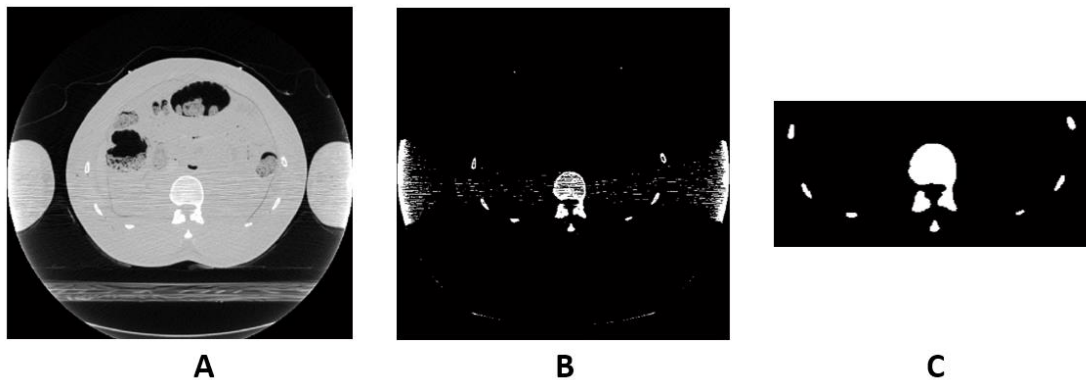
Segmentation on CT image with noise.
